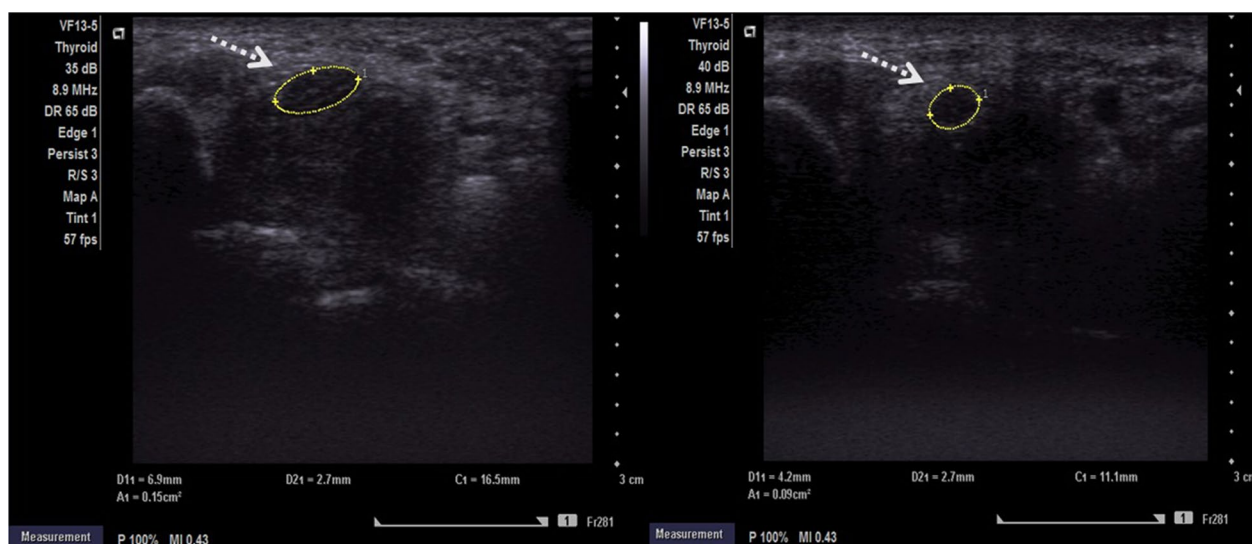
Ultrasound image of the median nerve (dashed arrow) of a 52-year-old patient with moderate CTS treated with ultrasound-guided injection. Before injection. CSA and FR were 15 mm² and 2.55 (left image), which improved to 9 mm² and 1.55, respectively, 4 weeks after injection (right image)
